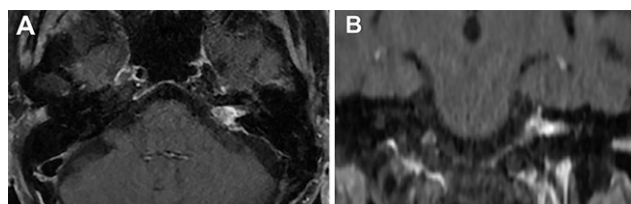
Postoperative imaging. Axial (A) and coronal (B) T1 MRI with contrast showing an expected subtotal resection with residual enhancing tumor within the IAC and resolution of brainstem compression.
